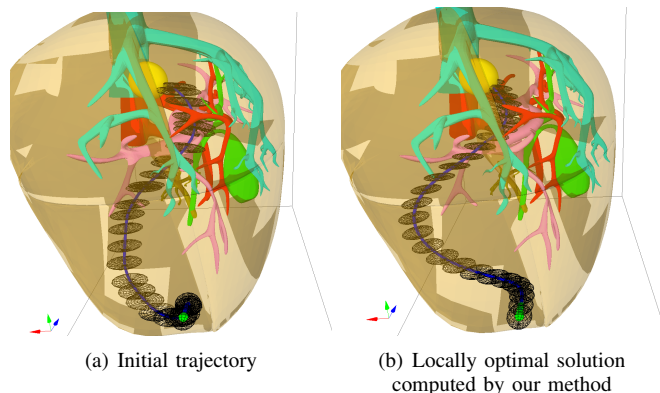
The objective is to steer the needle from a start pose outside the liver to a clinical target inside the liver while avoiding critical vasculature and ducts. We assume the sensing model is an X-ray imager pointing in the x direction (red arrow), which provides a 2D measurement of the tip's y and z position. (a) An initial trajectory computed using RRT. (b) A locally optimal solution computed using our method.
